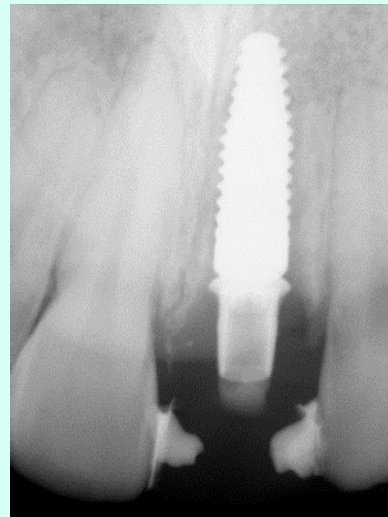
Periapical X-Ray.
